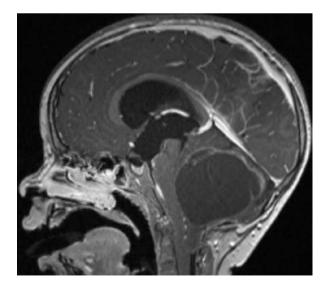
Posterior fossa pilocytic astrocytoma: Sagittal T1-Gad MRI showing a posterior fossa pilocytic astrocytoma in a 3-year-old. Tumor was resected
